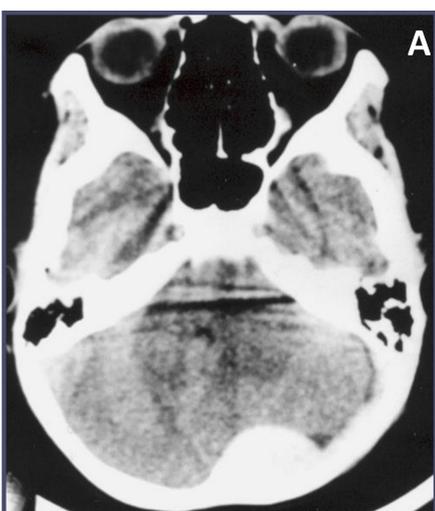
CT present a hiperdense lesion in left side at posterior skull base, compatible with epidural hematoma.
